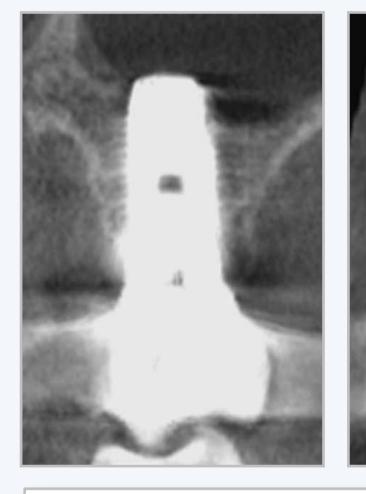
CB-CT at 1 year of implants 26 and 27 shows maintenance of crestal width.
